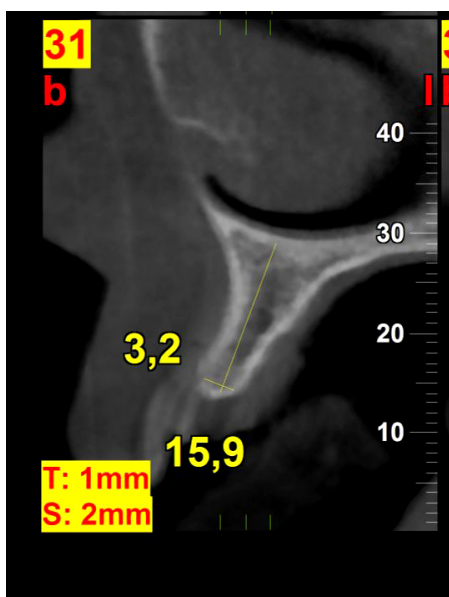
Initial sagittal cone-beam section of the alveolar process.
